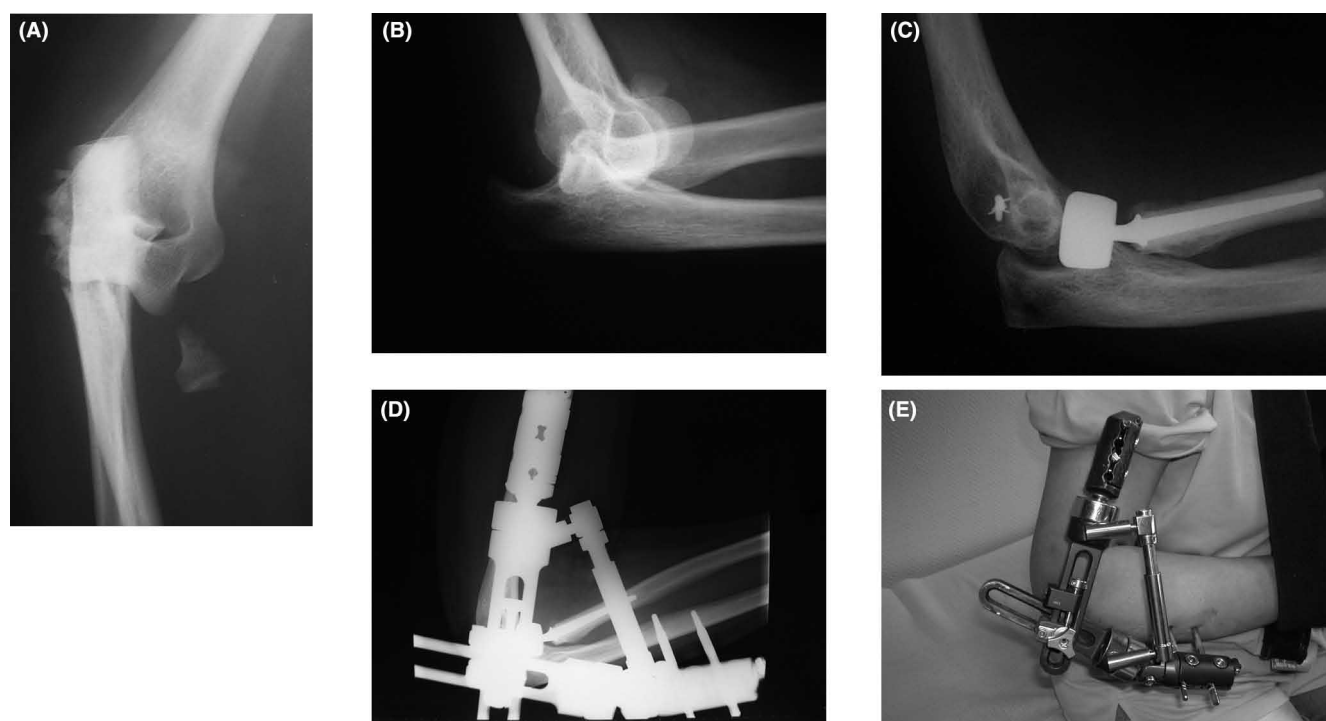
Terrible triad in a 43-year-old woman. (A and B) Lateral and AP views of a posterolateral dislocation of the elbow joint with associated radial head and coronoid process fractures. (C and D) Post operative radiographs before (C) and after (D) the application of an hinged external fixator. (E) Clinical aspect with the Exfix.
